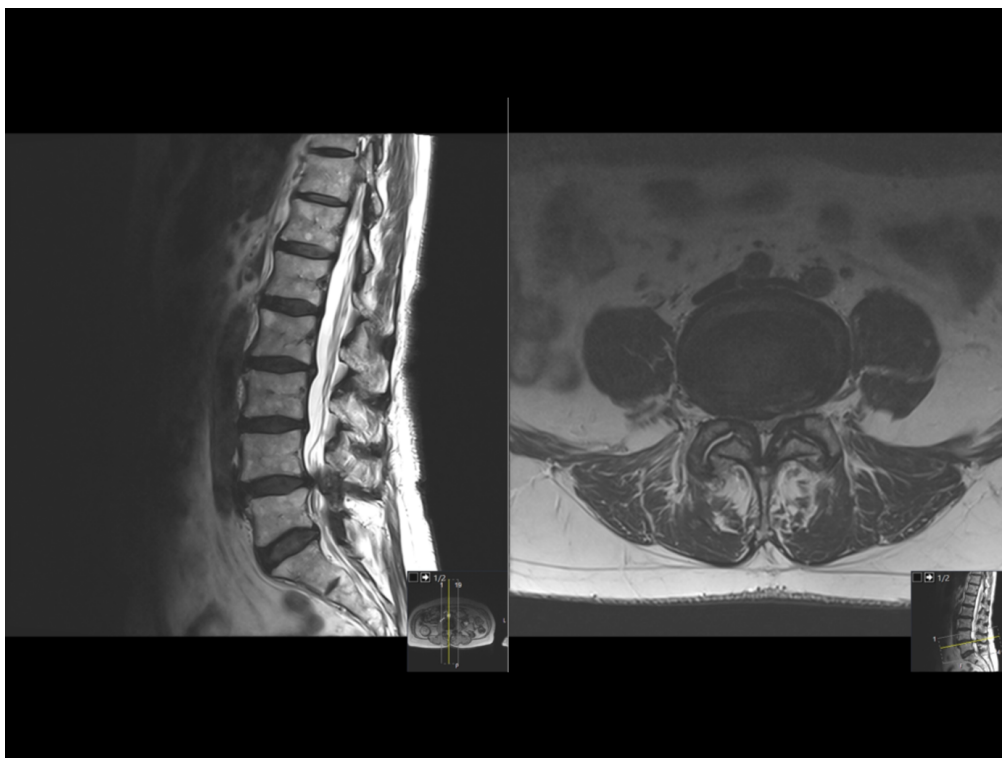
T2-weighted sagittal and axial MR images of lumbar spinal stenosis due to ligament and facet joint hypertrophy and an intervertebral disc bulge (provided by Prof Sasha Gulati).
